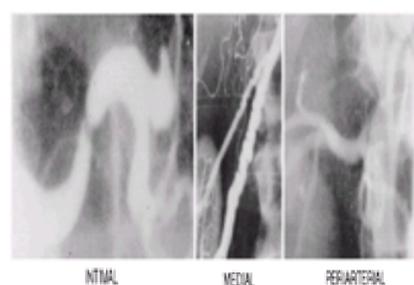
Representative radiographs of the three major types of fibromuscular dysplasia. (Reprinted from Lüscher TF, Lie JT, Stanson AW, et al. Arterial fibromuscular dysplasia. *Mayo Clin Proc* 1987;62:931-952, with permission.)
